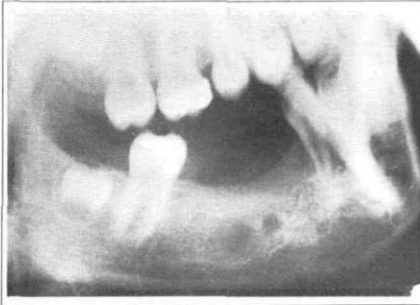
(left), 11 (right). Radiograph of surgical area 4 years postoperatively showing no recurrence of myxoma. Note placement of second molar which has erupted in the location of the first molar (Patient 2).
